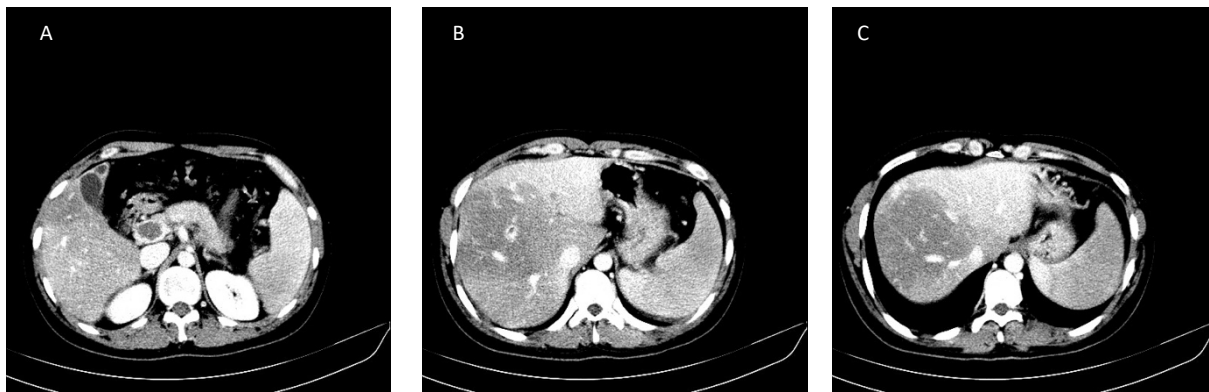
The CT scan results
